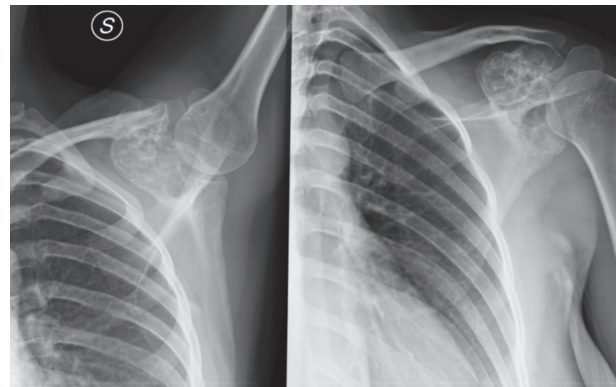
Preoperative radiography
